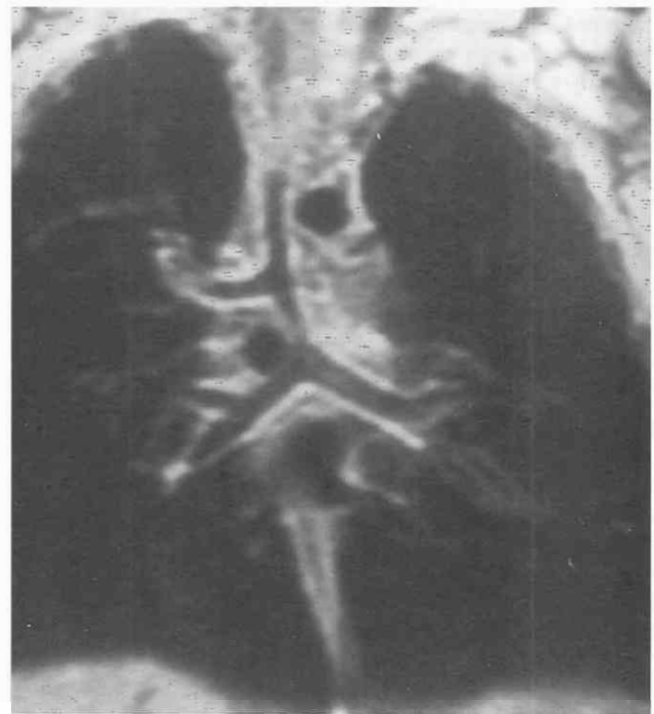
Respiratory distress in a 1-month-old infant. Coronal cross-sectional echocardiographic image through the trachea shows a bronchus suis.
